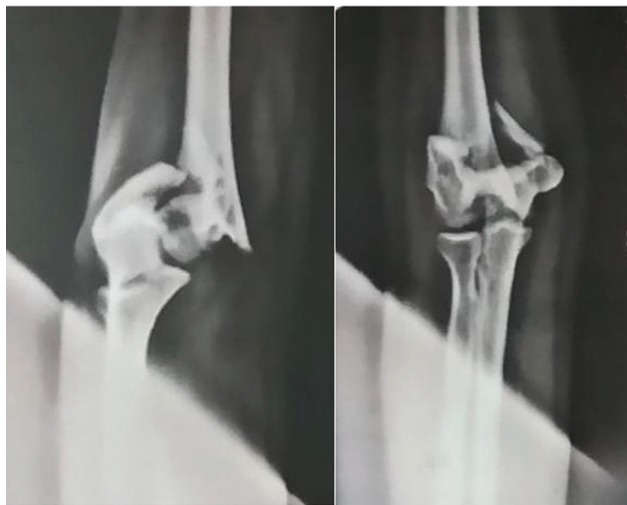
Case 2: triceps-reflecting approach; preoperative X-ray.
